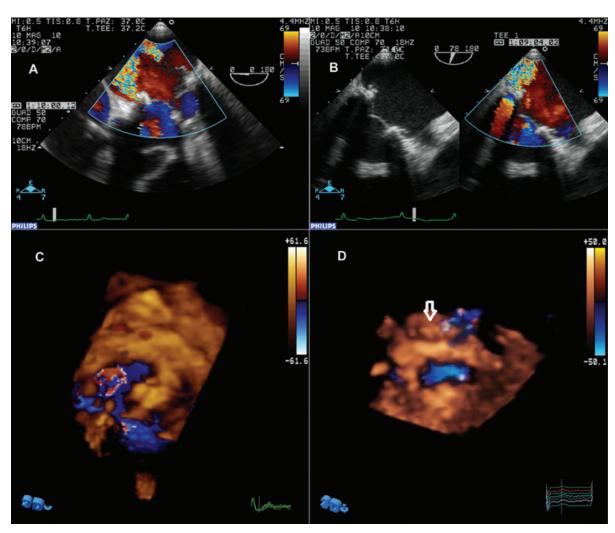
Transesophageal and transthoracic real time three-dimensional echocardiographic imaging. Identification and localization of the dehiscence area of the paravalvular leak was first accomplished with transesophageal echocardiography: the regurgitant jet was seen between 0° (panel A) and 75° (panel B) scan angle. At transthoracic real time 3D color Doppler echocardiography the position of the paraprosthetic leak was confirmed (panel C), whereas the device deployed through the leak (arrow) and the reduction of the regurgitant jet (panel D) were documented after the percutaneous closure procedure.
